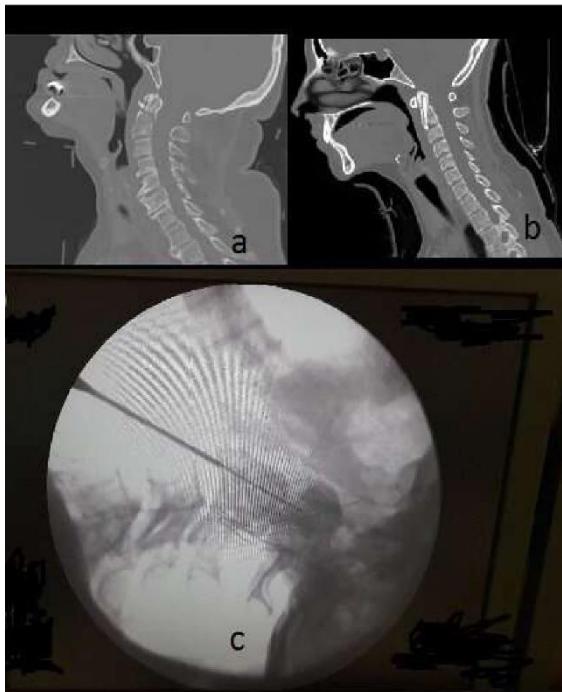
Pre-op type 2 odontoid fracture (a) and post-op CT image are seen (b). During surgery traction of guide is seen; placed in a gutter on C3 antero-superior part and oriented towards to fractured dens apex (c).
